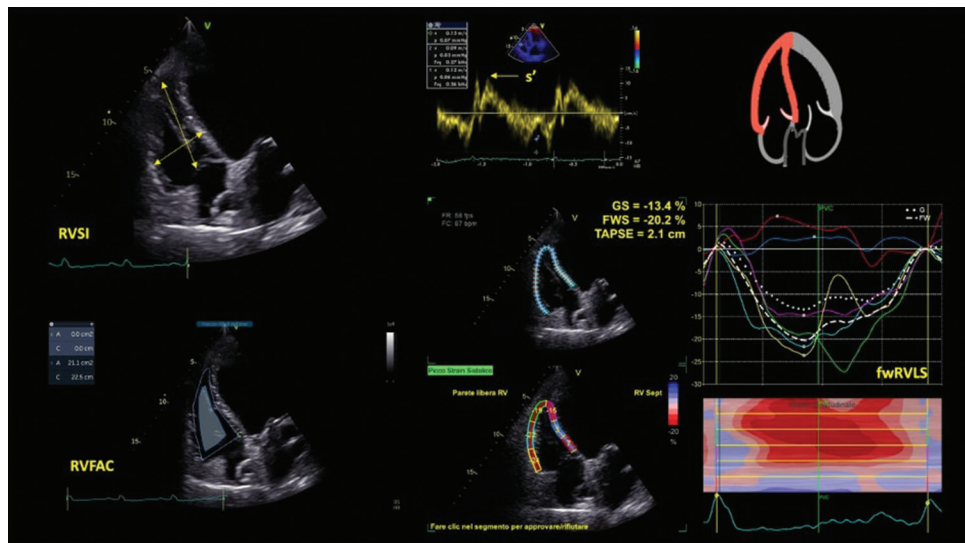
Echocardiographic parameters for the evaluation of the right ventricle in LVAD candidates. Right ventricular (RV) sphericity index on the top, left, assessed as the ratio between medium and longitudinal right ventricular diameters; tricuspid s' wave by tissue Doppler imaging on the top center; right ventricular fractional area change on the bottom, left, assessed as the ratio between (RV telediastolic area-telesystolic area) and RV telediastolic area; right ventricular strain, assessed by a new software which is able to automatically trace the endocardial contour of the RV based on three reference points put by the operator, and then generates the RV strain curves based on 6-segments model; thus calculating (1) RV global longitudinal strain (GS) including both free wall and interventricular septum, (2) free wall RV longitudinal strain including only three segments of the free wall, which is the recommended parameter in clinical practice, (3) tricuspid annular plane systolic excursion, in centimeters
